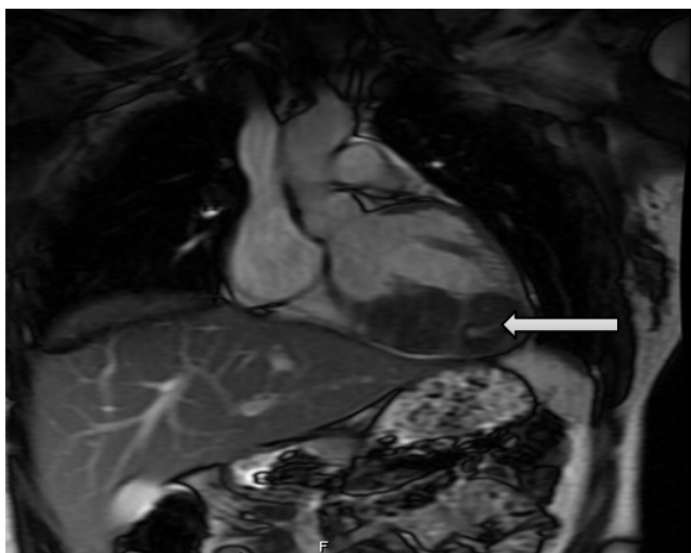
Cardiac MRI showing T2 hypointensity (white arrow), suggestive of fibrosis (cardiac fibroma).
